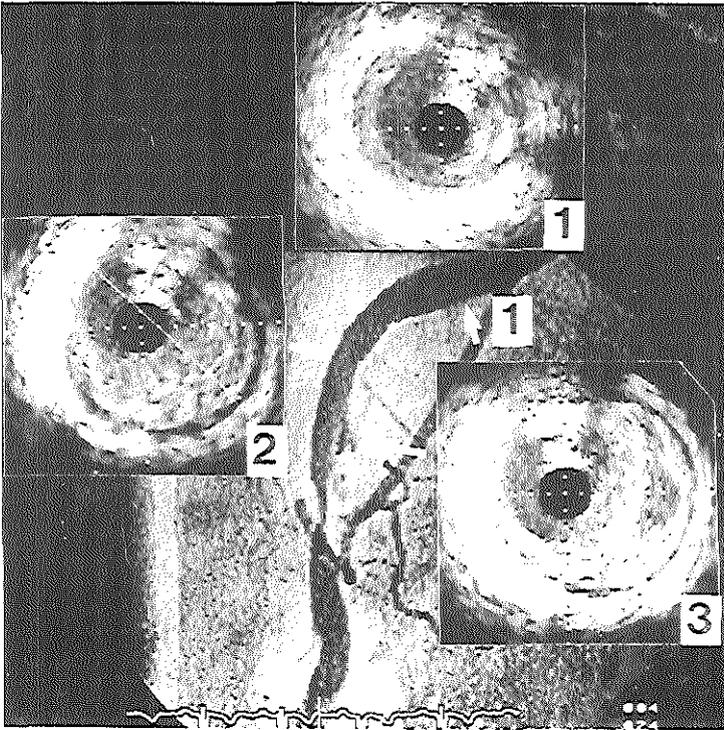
Digital angiogram of a proximal right coronary artery with a severe stenosis and extraluminal contrast in a patient treated with intracoronary thrombolysis. Intravascular ultrasound shows 1) a diffuse intimal thickening of the proximal artery; 2) a dilatation of the prestenotic artery, filled with inhomogeneous moderately echogenic material; 3) an echofree space in the plaque (at 3.00 o'clock) corresponding to the apparently extravasal contrast. During directional atherectomy thrombotic material at various stages of organization was retrieved.
